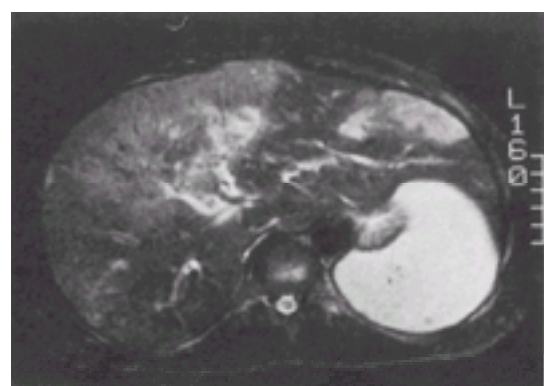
MRI scan of a 7-year-old boy with HCC (which appears white in this scan) demonstrates the multifocal nature of the tumor with involvement of both the right and left lobes.
